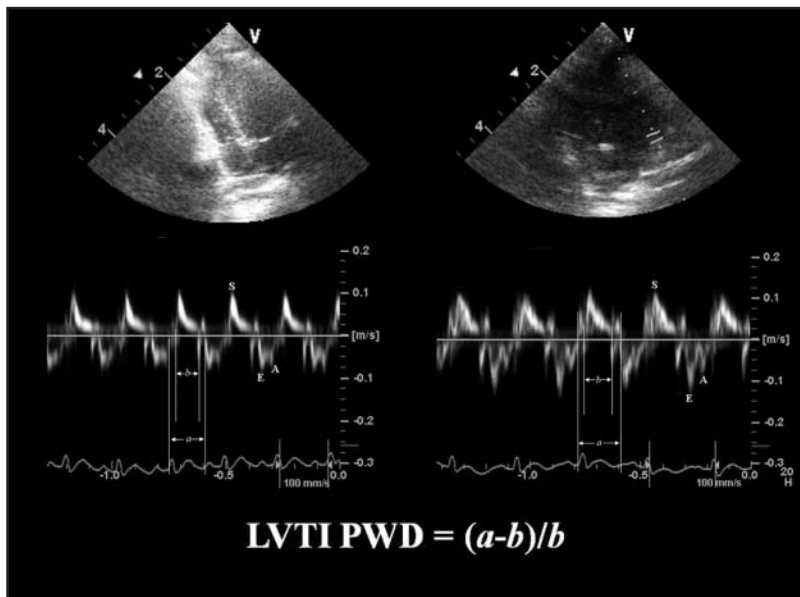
Tissue Doppler imaging recording of the interventricular septum (left panel) and left ventricular lateral wall (right panel) used to determine LVTI in a New Zealand White rabbit. Value *a* is measured from the trailing edge of late diastolic TDI mitral annular A wave to the leading edge of subsequent early diastolic TDI mitral annular E wave. Value *b* corresponds to the interval between the leading and trailing edges of the systolic TDI mitral annular S wave.
